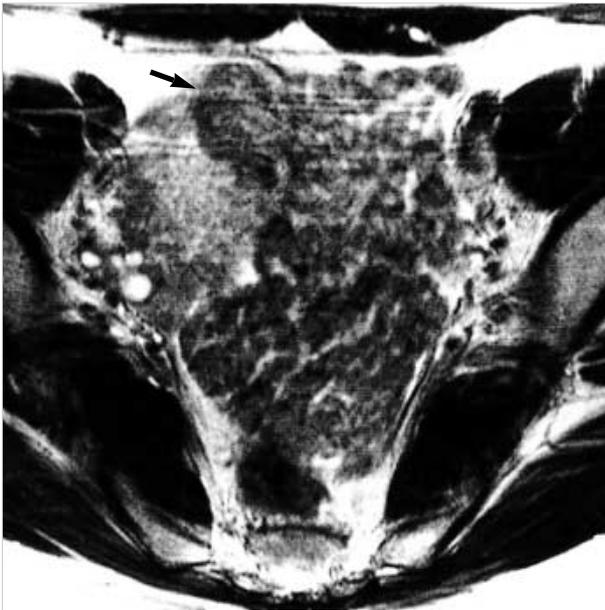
Pelvic MRI shows an exophytic heterogeneous mass lesion with low signal intensity in the left pelvic cavity as well as a small homogeneous intramural leiomyoma (arrow) in the uterine fundus.
